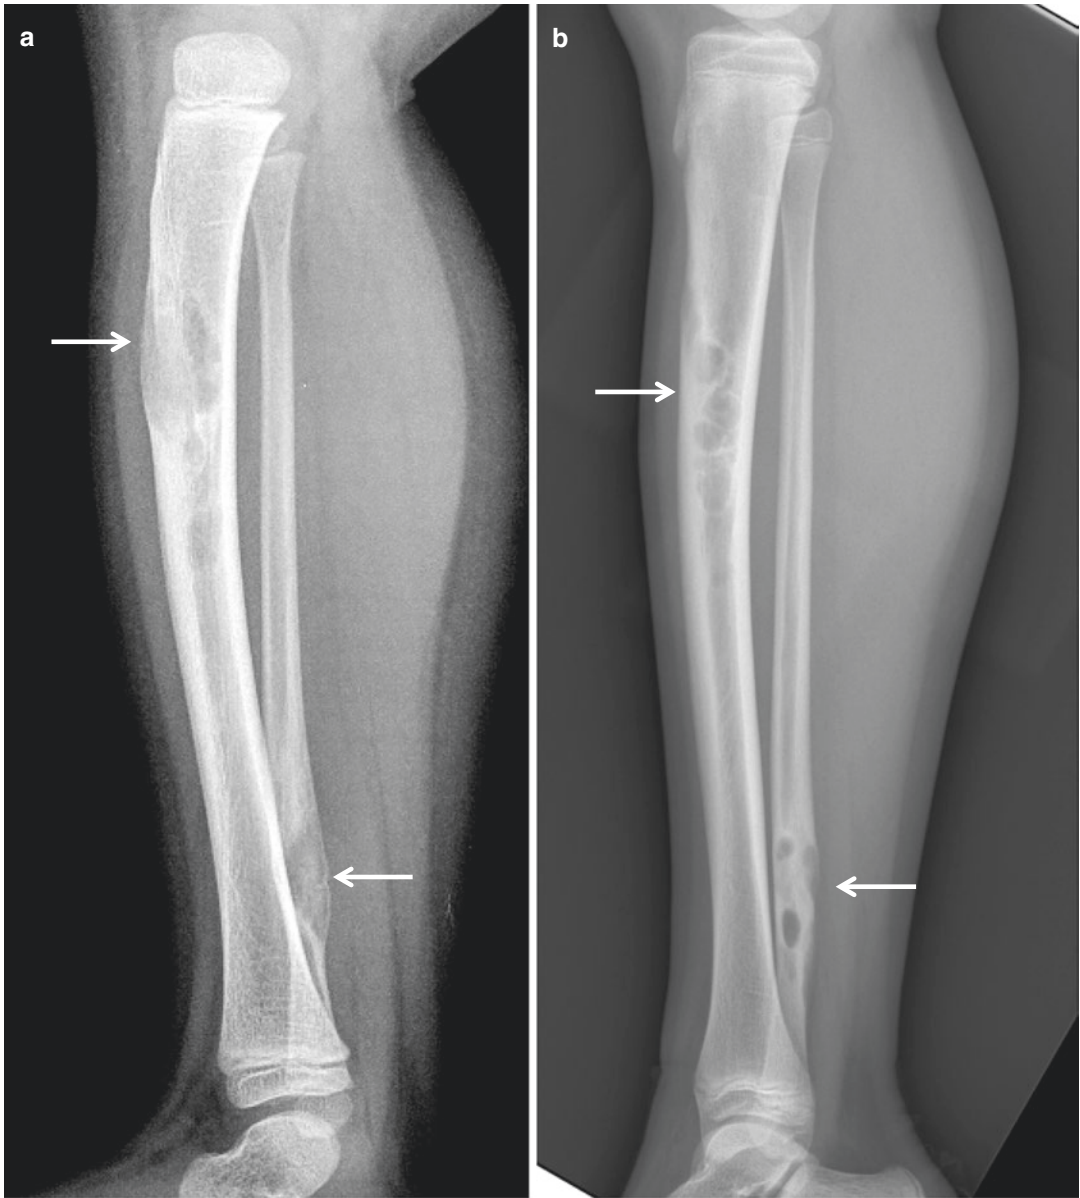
Osteofibrous dysplasia. (a) Anteroposterior and (b) lateral radiographs of the left lower leg of a 15-year-old female are shown. A well-defined osteolytic lesion is noted at the anterior cortex of the proximal shaft of tibia with a predominantly cortical location. (c) Markedly increased uptake is noted on bone scan. (d)
